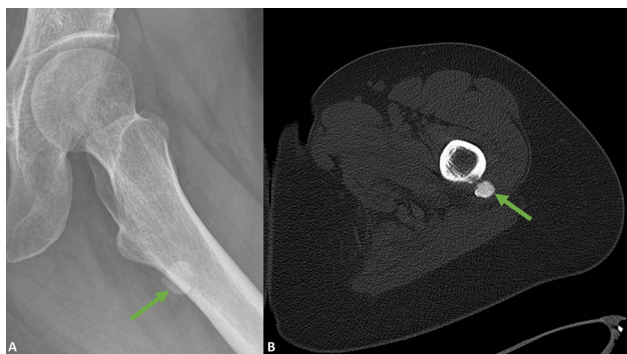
Lateral left hip radiograph (A) and axial CT image (B), obtained one year prior to symptom onset, demonstrate a focal, well-defined calcific density along the posterior aspect of the proximal femur (green arrow), corresponding to the gluteus maximus tendon insertion.
